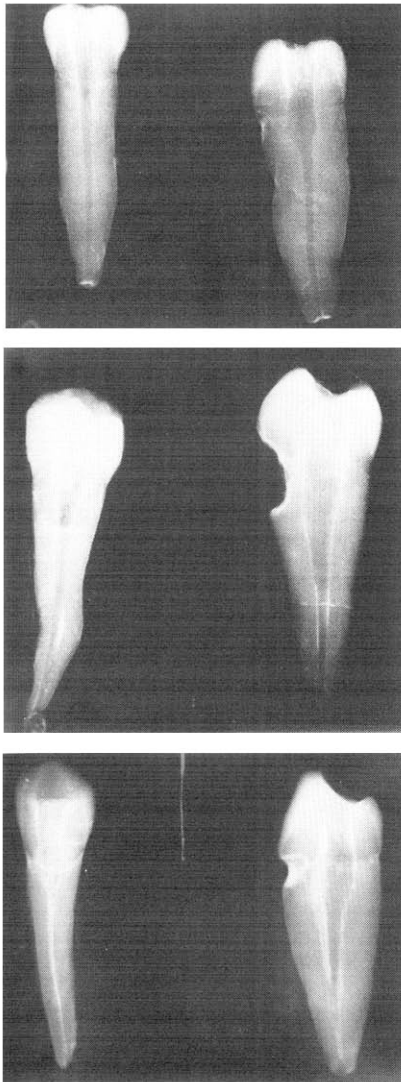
Radiographs show various levels of root canal debridement; evaluation included both apical (left) and coronal (right) sections. Top, radiograph received rating of 0; center, 1; and bottom, 2.
